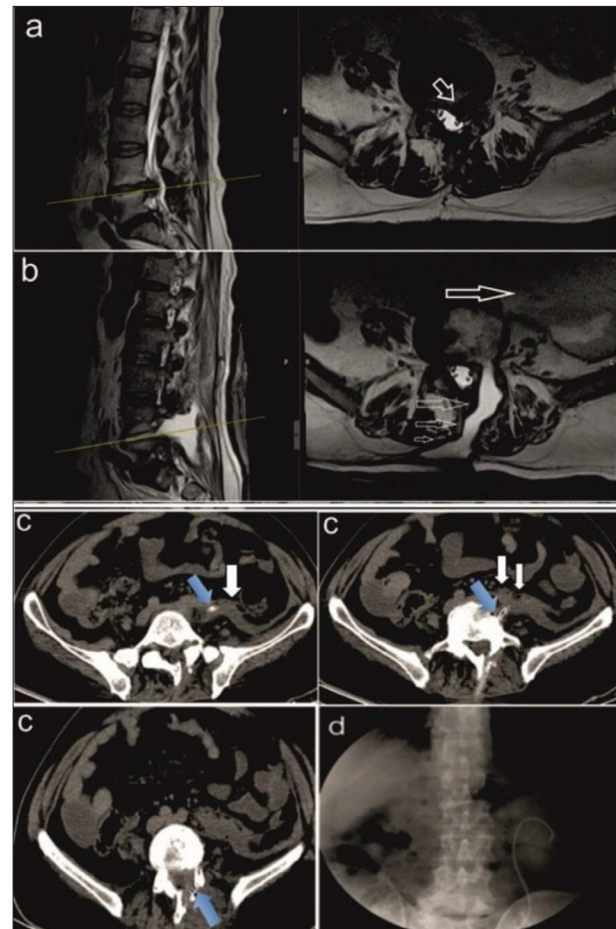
a – preoperative magnetic resonance imaging showing right-sided extruded disc herniation at L4–L5 (white arrow); b – postoperative magnetic resonance imaging showing a urinary fistula (thin white arrow) extending from the urinoma sac (thick white arrow) to the disc height and further to the skin; c – postoperative computed tomography showing the drainage catheter (blue arrow) extending from the urinoma sac to the skin (white arrow); d – intravenous pyelography showing that the catheter cannot go above the disc height where the injury occurred
